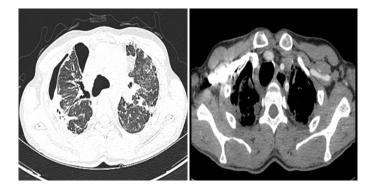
Thorax CT findings of the PPFE patient showing pleural thickening, pneumothorax, subpleural fibrosis, and suprasternal notch deepening [36].
